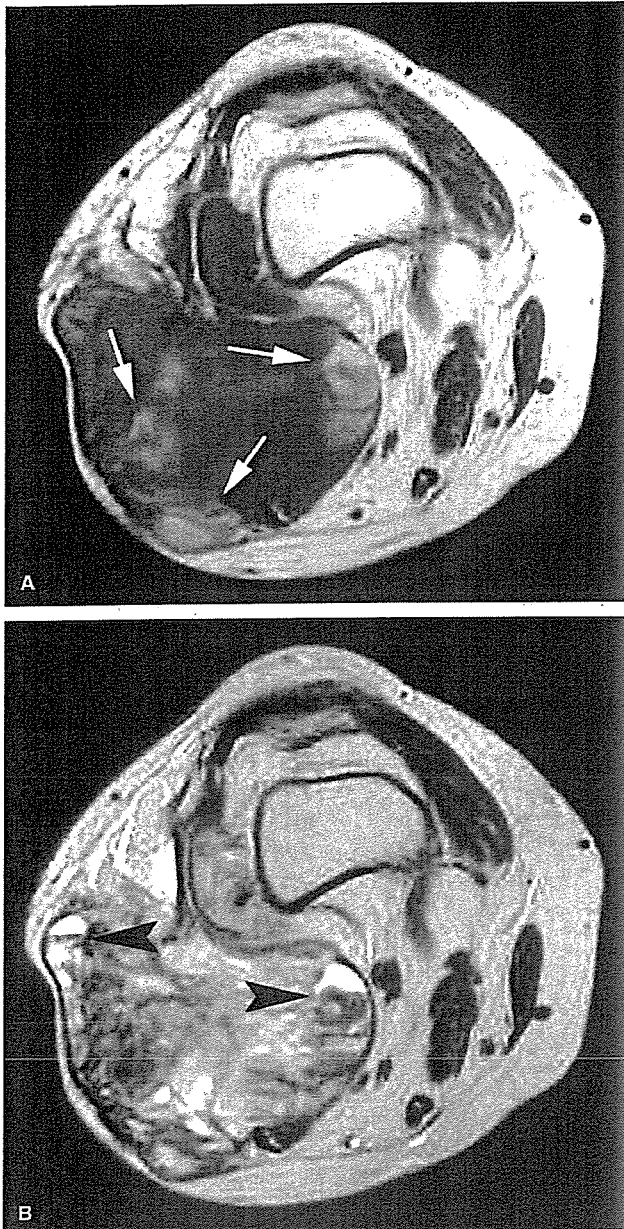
A 57-year-old woman with synovial sarcoma (high-grade) in left knee. A, Axial T1-weighted spin-echo (TR/TE: 720/50 milliseconds) MR image at the level of distal femur shows irregular soft tissue mass with multiple areas of high intensity signals (arrows). B, Axial T2-weighted fast spin-echo (3500/100) MR image shows fluid-fluid that suggests the presence of hemorrhage at the same location (arrowheads).
